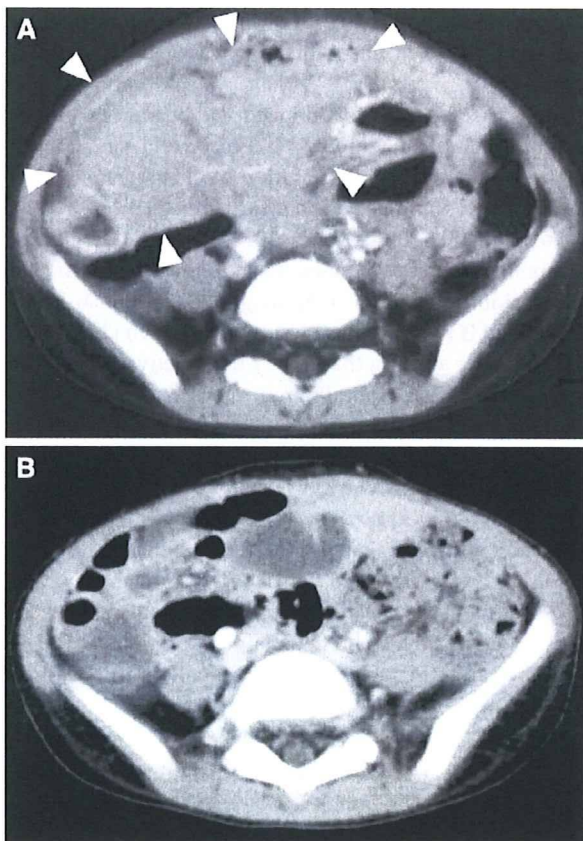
CT scan images. Abdominal enhanced CT scan showing an ileocecal mass (*arrowheads*) at diagnosis (a) and dramatic disappearance after the first course of combination chemotherapy (b)
